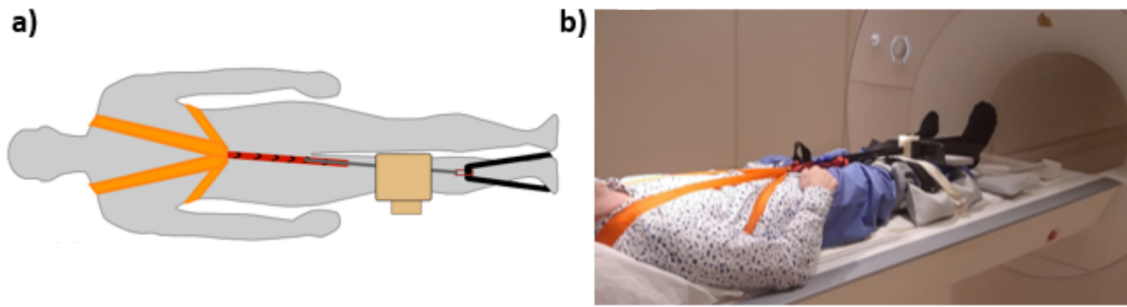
Pulley system device in MRI acquisition set-up [32].
